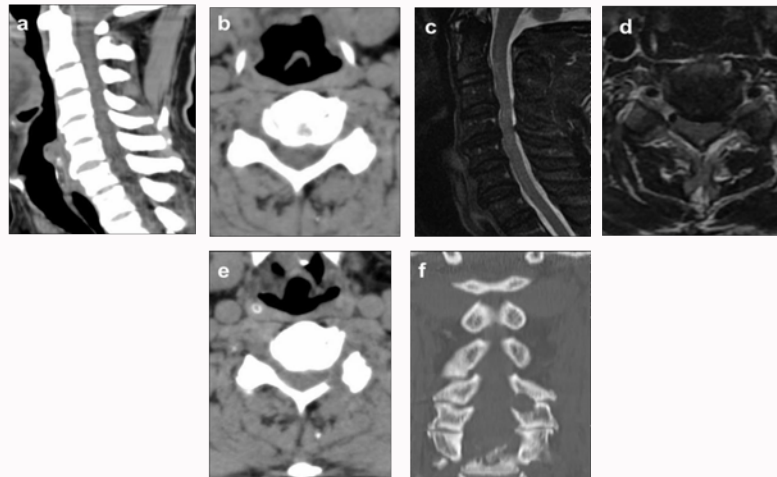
A classic case report, a 48-year-old female patient with osseous foraminal stenosis at C5/6 a. Preoperative cervical CT scan (sagittal); b. Preoperative cervical CT scan (Horizontal position); c. Preoperative cervical MRI scan (sagittal); d. Preoperative cervical MRI scan (Horizontal position); e & f. Cervical CT scan showed nerve root canal enlarged and nerve root relaxed at 1 week after operation.
